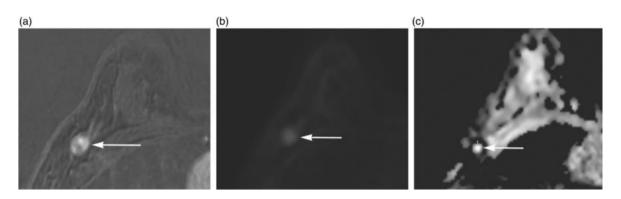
(ii): A 57-year-old woman with a surgically verified benign lymph node. (a) Axial early DCE 3D T1-weighted subtraction 3.0-T MR image of the right axilla shows a enhancing lymph node (arrow). (b) Axial single shot-spin-echo planar DWI high signal intensity of the lymph node. (c) Axial ADC map (b value, 1000 mm²/s) shows unrestricted diffusion (arrow), the mean ADC of the lesion was 1.26 x 10⁻³mm²/s.
